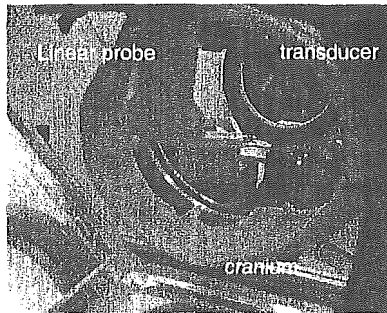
Experimental setup for obtaining ultrasonic B-mode image of bubble formation.
